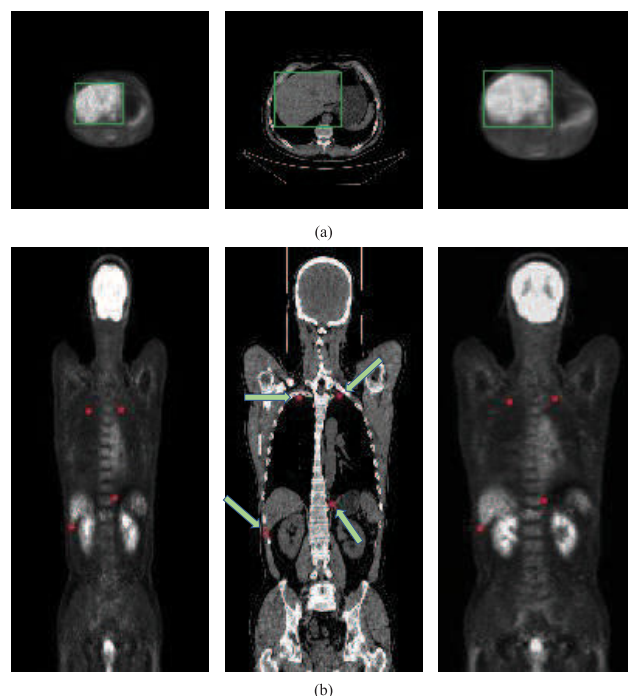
Visualization of liver bounding box and landmark points in both PET and CT used for calculating IoU and ED. The 1 - 3th column from left to right are corresponded to the source PET image, the source CT image and the deformed PET image. (a) Liver bounding box, shown in green, (b) Landmark points, shown in red.
